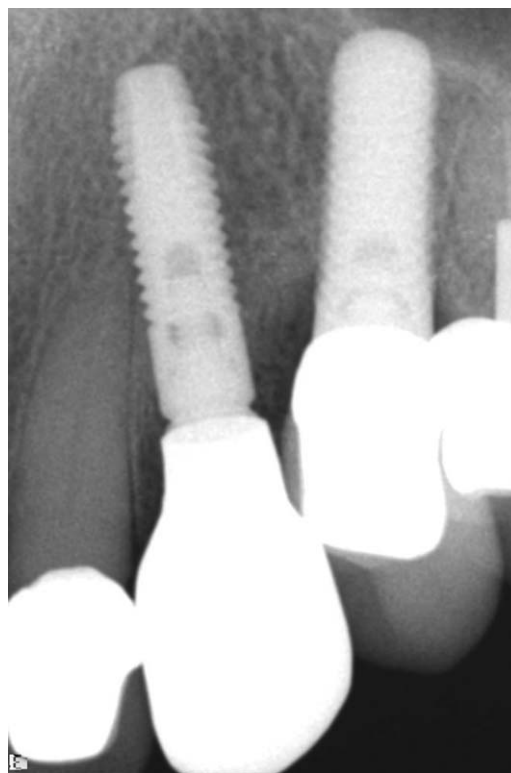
A, The dermal allograft is “tucked” into the pouch created by blunt dissection between the facial and palatal bone and periosteum and secured with a horizontal mattress suture. B, Postoperative radiograph taken at the completion of immediate placement and provisionalization.
